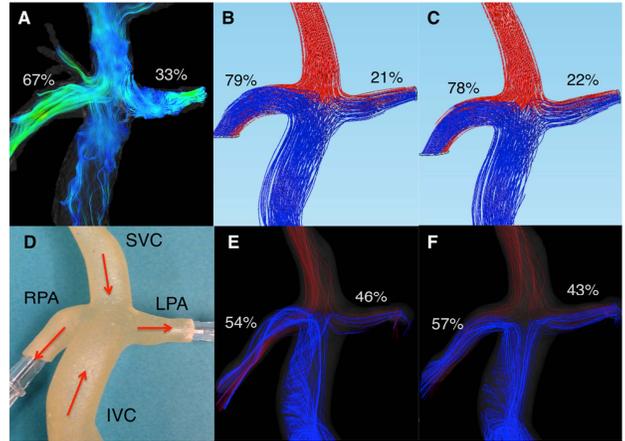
4D Flow MRI on a 2YO extra-cardiac TCPC patient compared to patient-specific physical and CFD models. A. *In vivo* velocity color-coded streamlines. B. *In silico* results at baseline flow (1 L/min). C. *In silico* results at increased flow (1.8 L/min). D. Patient-specific physical model fabricated from MRI using SLS. E. *In vitro* results at baseline flow. F. *In vitro* results at increased flow. For B, C, E and F, blue and red streamlines represent IVC and SVC flow, respectively. Flow into each PA is shown as percent of the total outflow.
